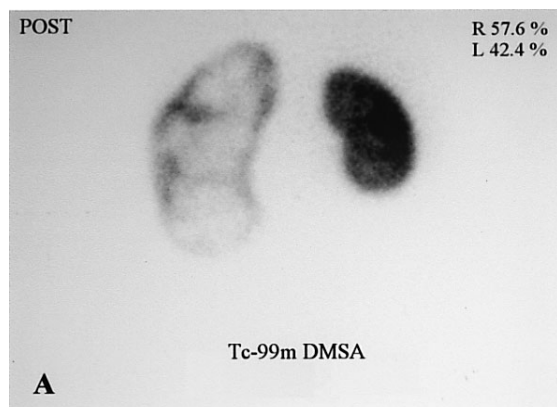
An 8-year-old boy with unilateral hydronephrosis in the left kidney caused by the presence of ureteropelvic junction stenosis. Tc-99m DMSA and Tc-99m EC summed images show the same scintigraphic appearance concordant with hydronephrotic left large kidney.
